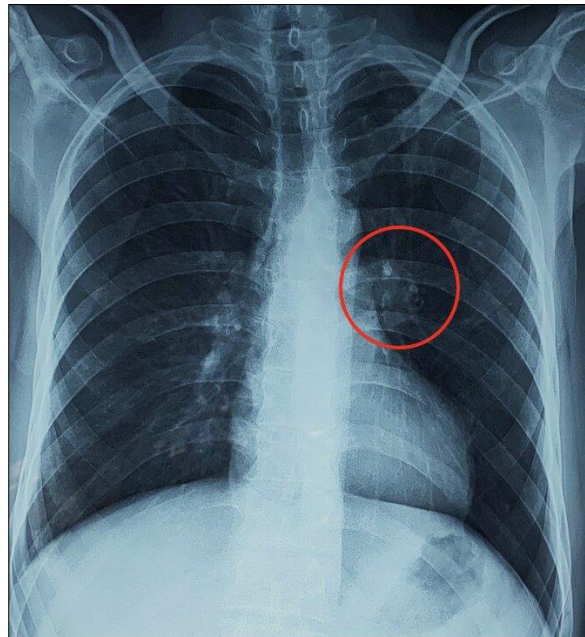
Chest X-ray showing a left hilar opacity
